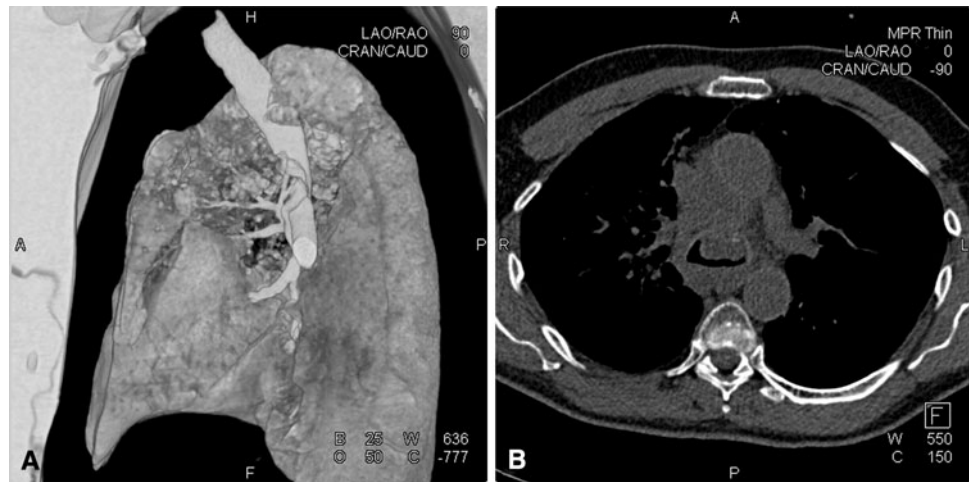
Patient # 2: a A volume-rendered 3D CT image showing the same (note what is left of the tracheal lumen after removal of the mediastinal mass from the image). b CT showing the size of the anterior mediastinal mass with tracheal compression (note the very small flattened tracheal lumen) and right main stem bronchus intrusion
